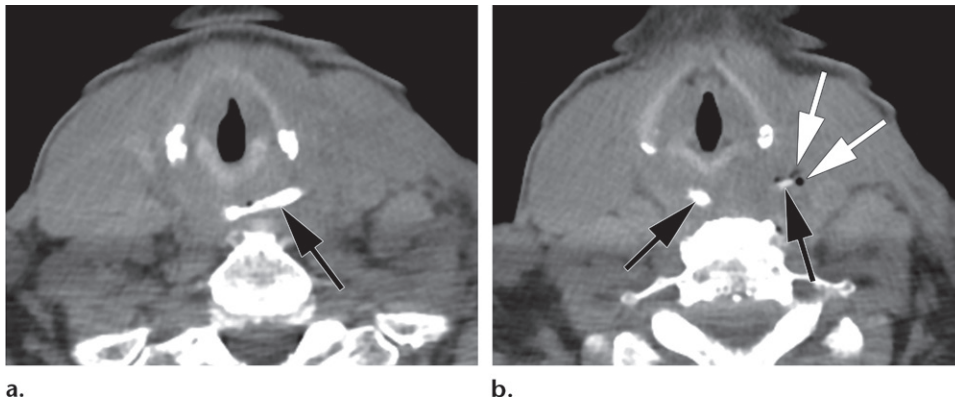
Impacted chicken bone in a 78-year-old woman. Axial nonenhanced CT images show the radiodense bone (black arrows) in the cervical esophagus, posterior to the larynx. There is gas (white arrows in b) within the adjacent left lateral soft tissues, consistent with perforation. Rim enhancement cannot be assessed because contrast material was not administered.
